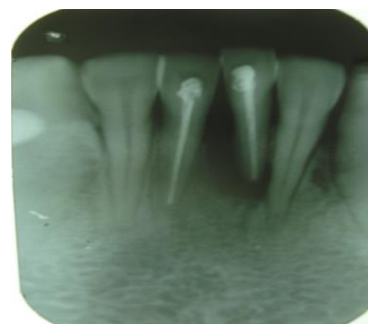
Pre-operative radiograph showing extensive bone loss with 31 & 41
